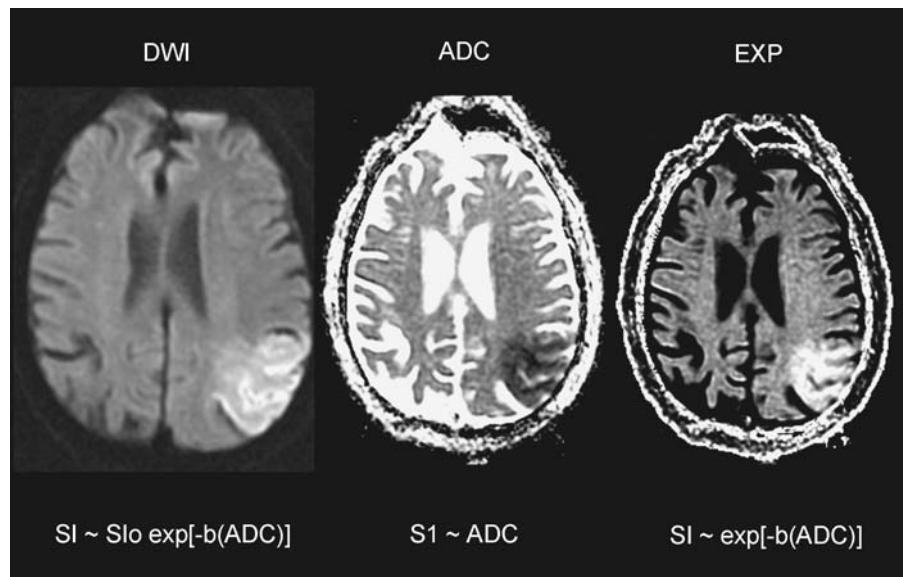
Typical diffusion MR image maps. DWI, ADC map, and EXP images along with the corresponding mathematical expressions for their signal intensities are shown. Image parameters are $b = 1000 \text{ sec/mm}^2$; effective gradient, 25 mT/m; repetition time, 7500 milliseconds; minimum echo time; matrix, 128×128 ; field of view, $200 \times 200 \text{ mm}$; section thickness, 5 mm with 1 mm gap. The acute left parietal stroke has restricted diffusion characterized by hyperintensity on the DWI and EXP images and hypointensity on the ADC maps. Abbreviations: DWI, diffusion-weighted image; ADC, apparent diffusion coefficient; EXP, exponential; SI, signal intensity, S_{Io}, signal intensity on echo planar T2-weighted image.
